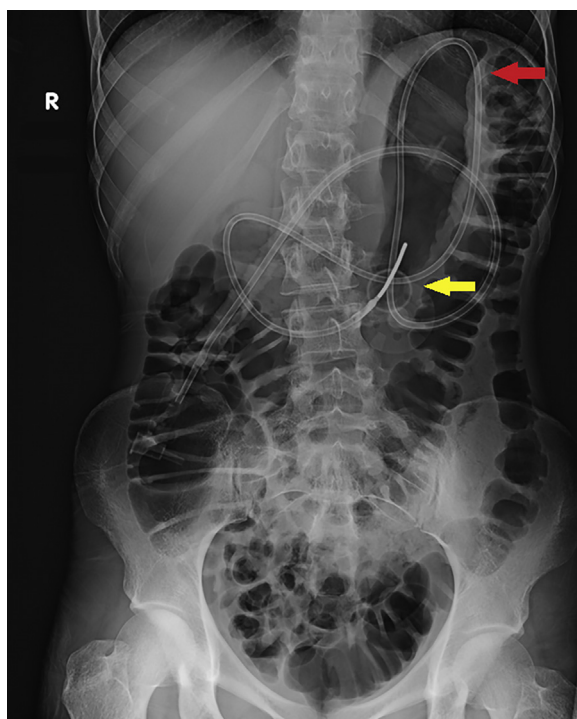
Radiograph showing percutaneous endoscopic gastrostomy with jejunal extension entering the skin (*yellow arrow*) and jejunal extension looping within the stomach (*red arrow*).
